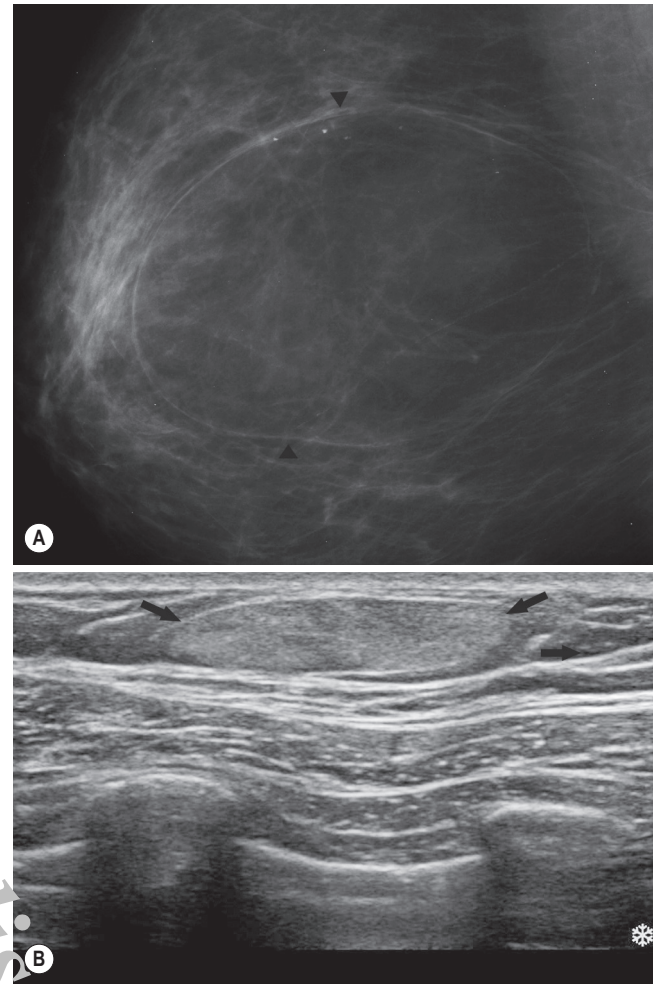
Lipoma. (A) On mammography, a lipoma may be seen as a well-defined mass of fat density, contained within a thin capsule (arrowheads). (B) On ultrasound, a well-defined hyperechoic lesion characteristic of a lipoma is seen (arrows).
